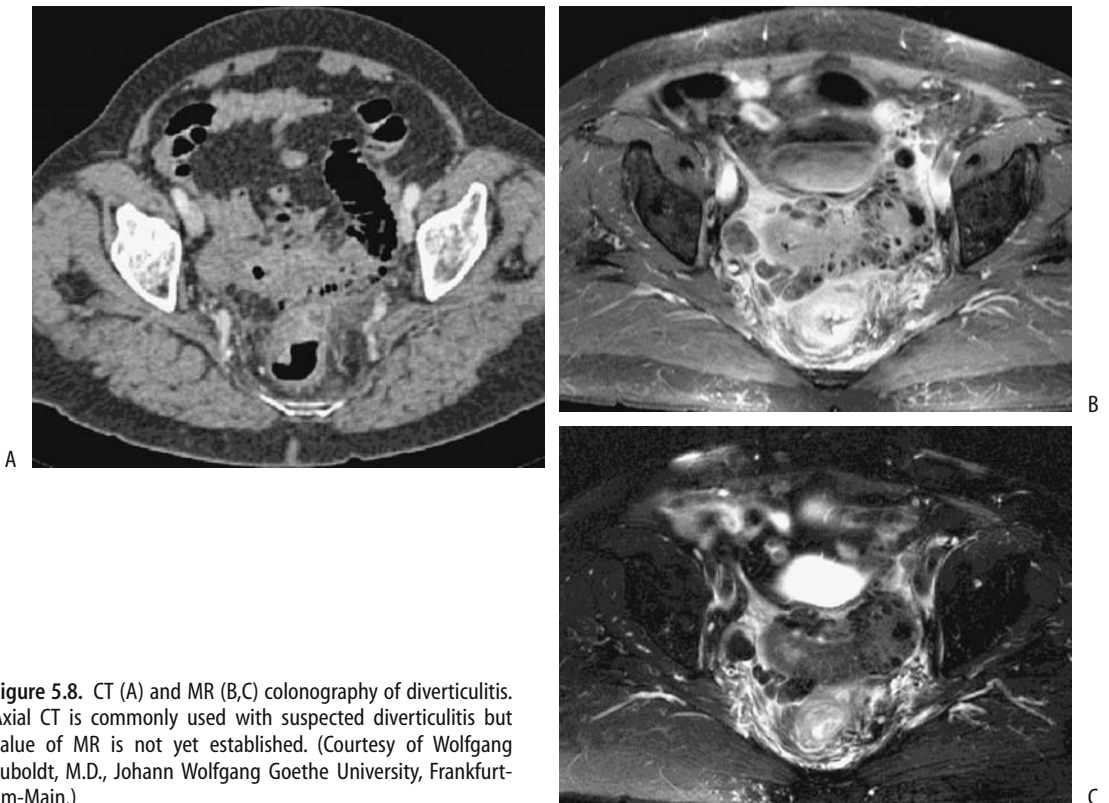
CT (A) and MR (B,C) colonography of diverticulitis. Axial CT is commonly used with suspected diverticulitis but value of MR is not yet established. (Courtesy of Wolfgang Luboldt, M.D., Johann Wolfgang Goethe University, Frankfurt-am-Main.)
